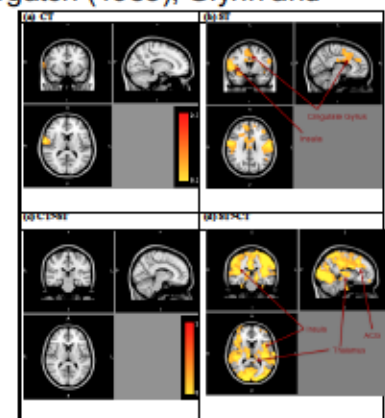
BOLD Activation during CT and ST with Adults with Alcohol Dependence
